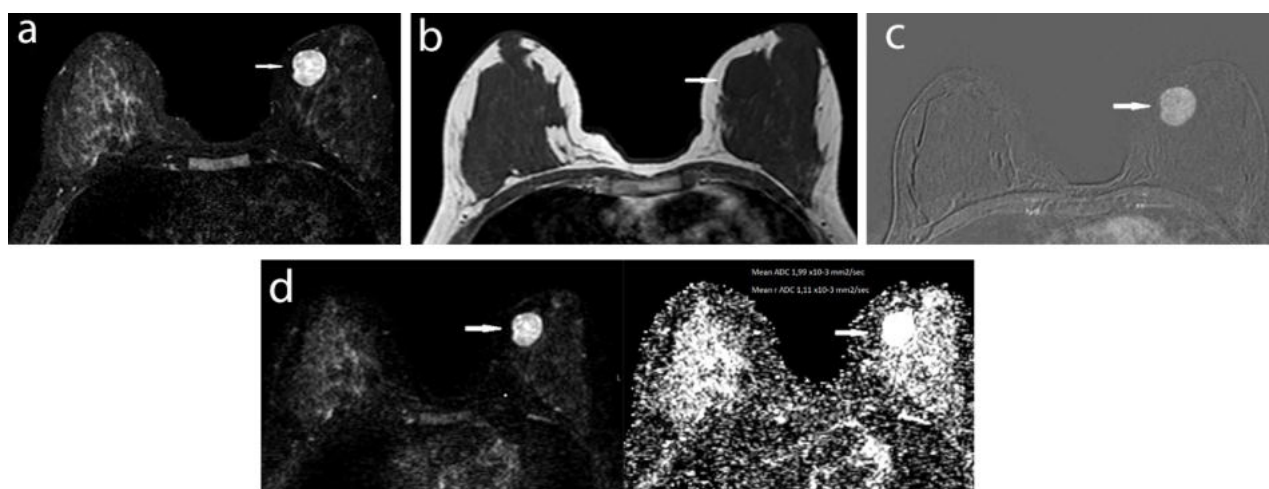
(a) A well circumscribed 20 × 15 mm mass in the left upper-inner-quadrant of left breast, hyperintense in T2 weighted images; (b) hypointense in T1 weighted images; (c) homogeneously diffuse enhancing (arrow) in T1 weighted post contrast images; and (d) Non-restricted in DWI with ADC $1.99 \times 10^{-3} \text{ mm}^2/\text{s}$ and r ADC $1.11 \times 10^{-3} \text{ mm}^2/\text{s}$. The pathology report showed fibroadenoma.
